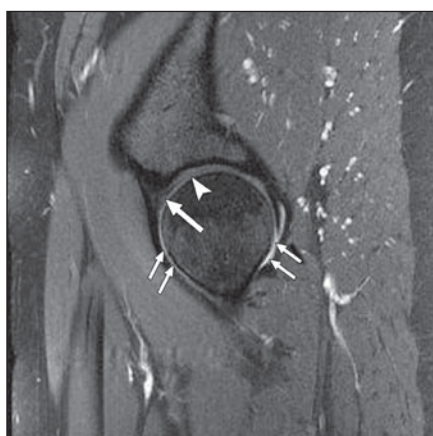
Sagittal oblique T1-weighted image, with fat suppression, after IV gadolinium injection with exercise and delay in 52-year-old man depicts low-signal anterior superior labrum (*large arrow*) and subjacent intermediate signal hyaline articular cartilage (*arrowhead*). Note enhanced joint fluid (*small arrows*) resulting in an “arthrographic effect.”
